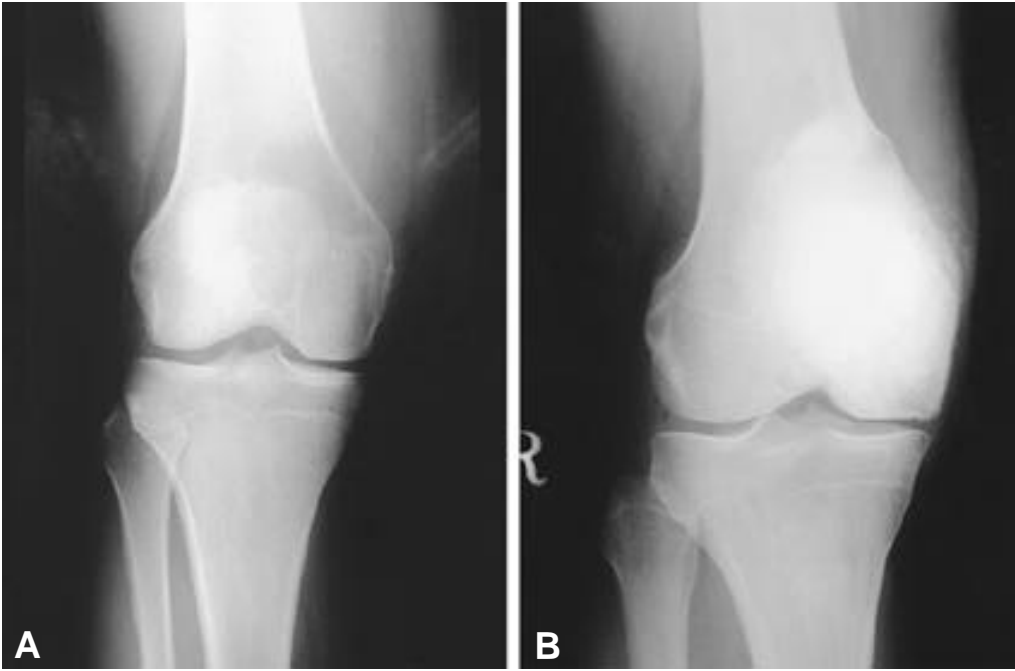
36-year old patient with giant cell tumor of distal femur. (A) Plain radiograph shows a large epi-metaphyseal osteolytic lesion extending close to joint. (B) The articular surface of the medial femoral condyle has been maintained without evidence of collapse at 3 years after primary surgery (curettage, cryosurgery and cementing).
